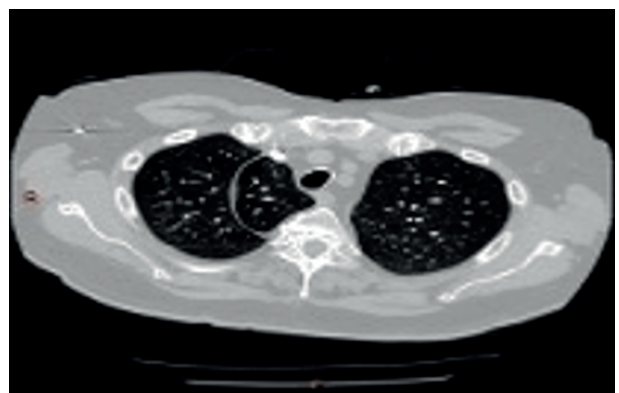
Azygos lobe and fissure on the thorax CT.
